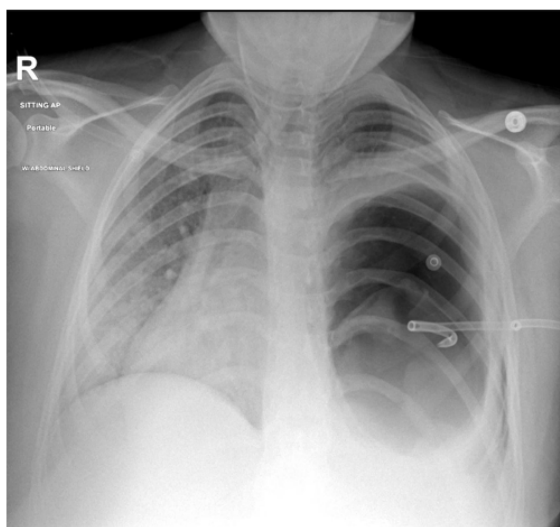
A chest X-ray showed a left-sided pigtail drain in situ with a large left cystic lesion causing compression of the adjacent lung and a mediastinal shift to the right, with a ground glass change seen in the right lung
